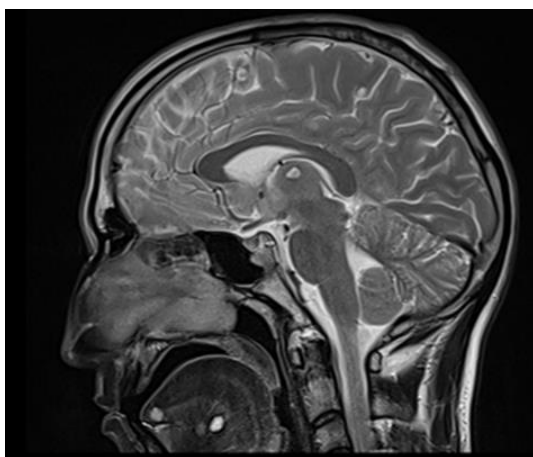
MRI Sagittal T2WI through the upper cervical region: High signal oblong shaped cystic lesions in the extrinsic muscles of the tongue.
